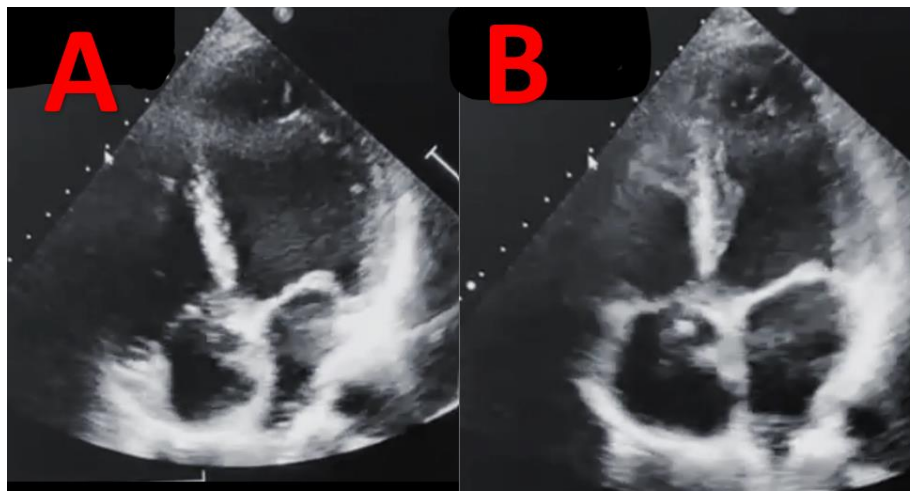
Trans-thoracic echocardiography (TTE) conducted prior to pacemaker placement showed a standard apical 4 chamber image, which indicated the presence of normal end-diastolic (A) and end-systolic (B) dimensions, together with a conserved ejection fraction of 60%.
